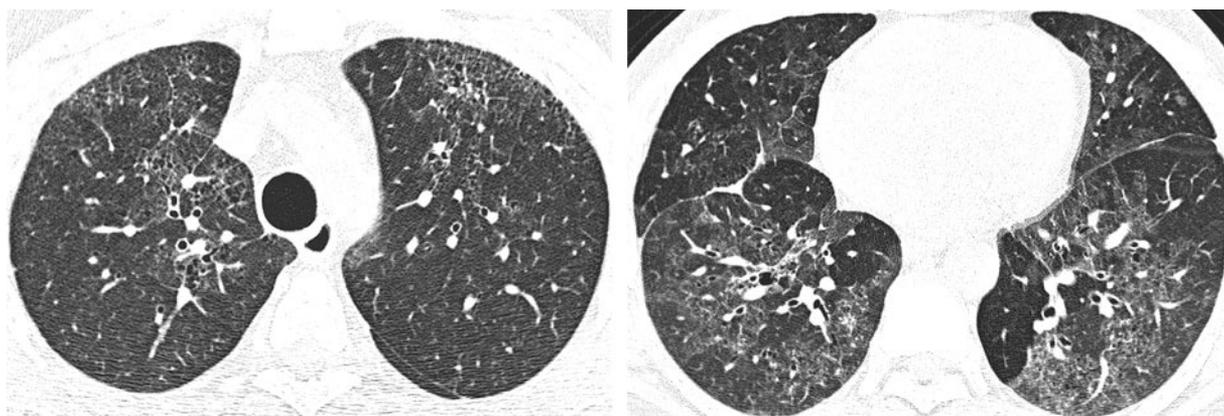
Pulmonary fibrosis in a 38-year-old woman with a long-term history of crack cocaine smoking. (a) Chest CT scan demonstrates bilateral, predominantly anterior reticular opacities and honeycombing. (b) On a CT scan obtained inferior to a, the opacities have a predominantly ground-glass appearance.
